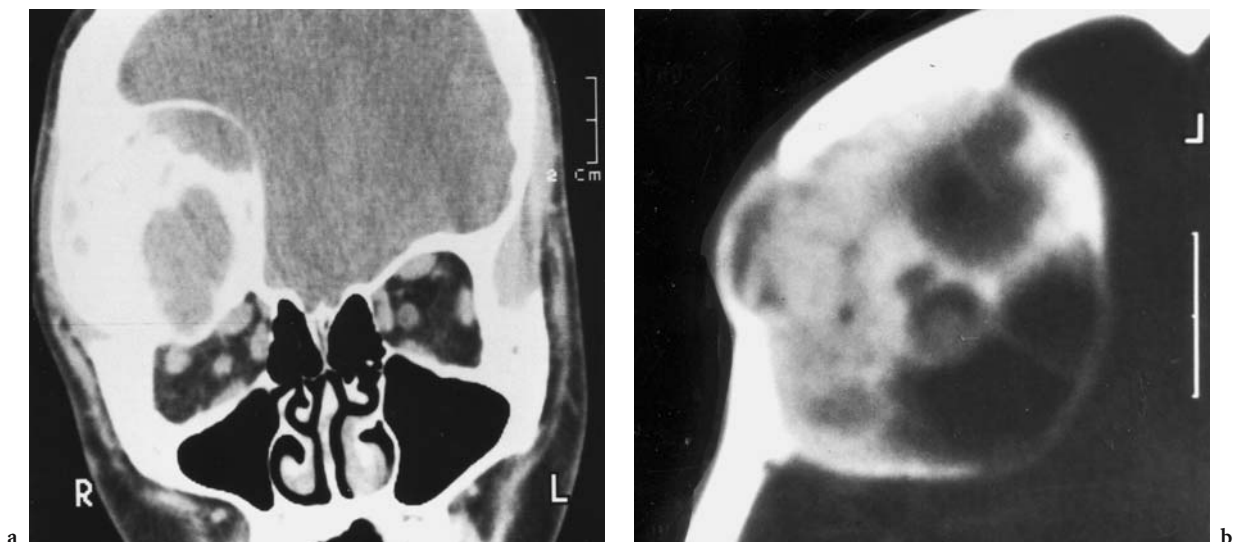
A 14-year-old girl with slowly progressing, right-sided orbital protrusion and inferior dislocation of the globe developing over a period of several years. Diagnosis: aneurysmatic bone cyst associated with fibrous dysplasia (Jaffé–Lichtenstein disease). CT: a Coronal view with extracerebral intraosseous lesion of the right frontal bone, expanding to the orbital roof and to the orbit itself; a comparison with the left side confirms caudal dislocation. b Axial (sectioned) view in bone window, showing rare configured, chambered, snail-shell-shaped thickening of the diploë of the right frontal bone, consisting of a partly cystic, partly solid portion, causing superficial destruction of the external tabula
